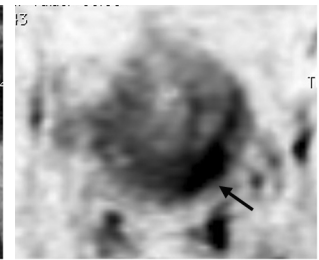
Fusion image of DWI and MRU
